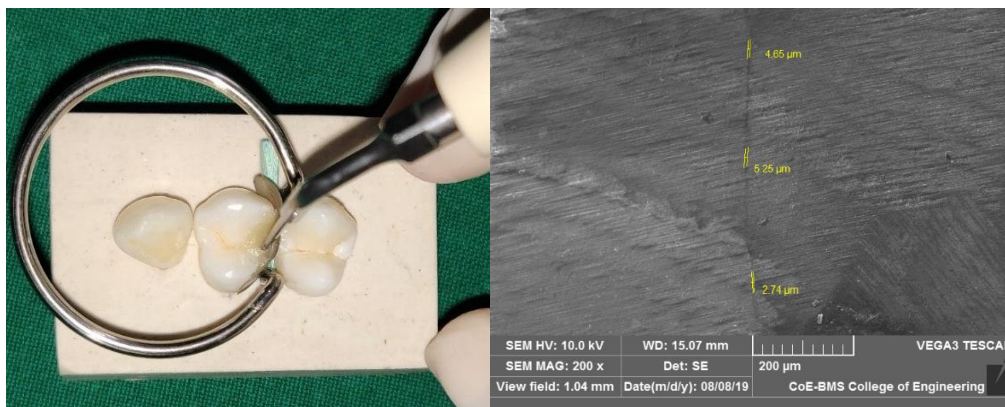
a- Ultrasonic plasticization, b- SEM image from ultrasonically plasticized group.
